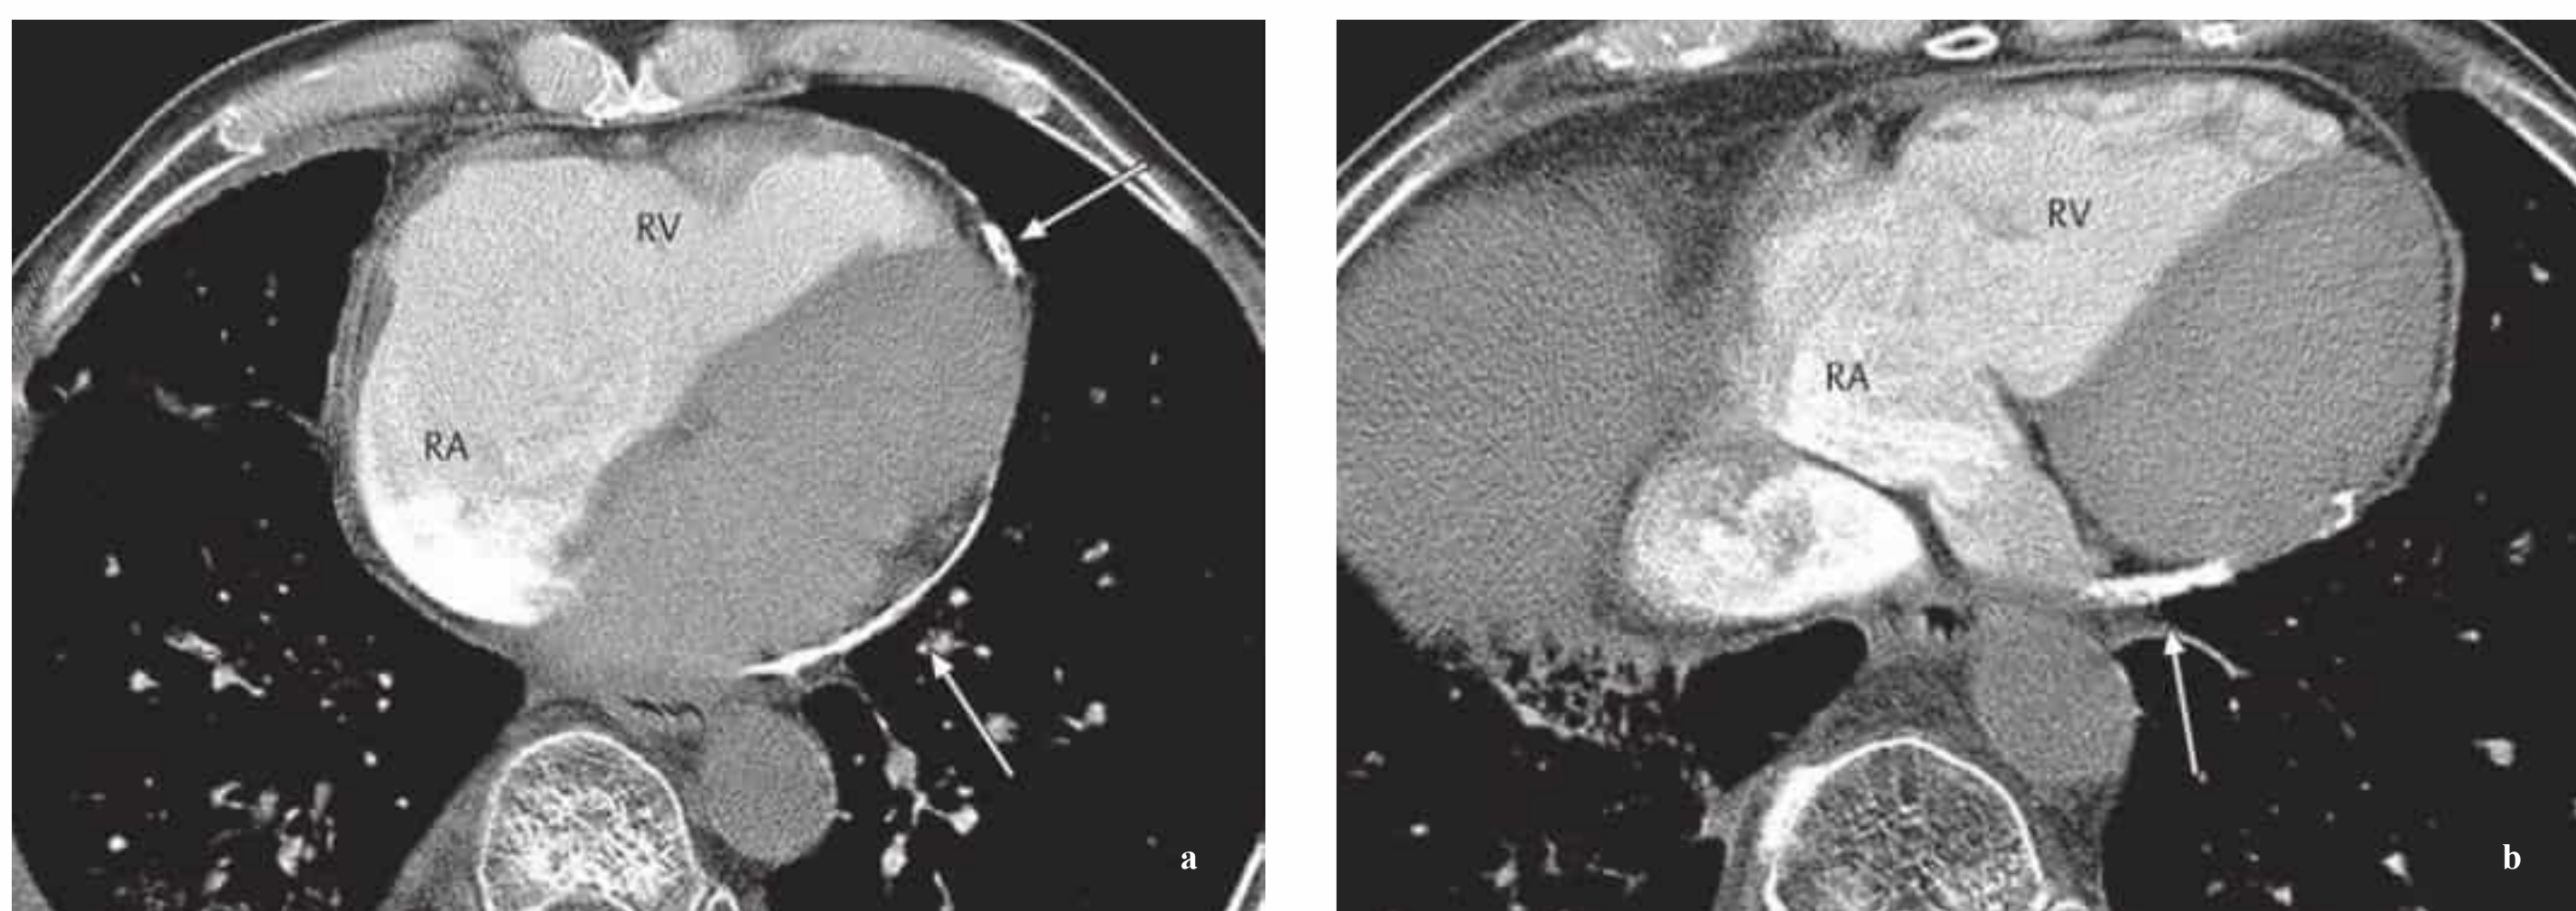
a, b Pericardial calcification (arrow) in constrictive pericarditis, depicted by CT. Note the enlargement of the right atrium.
